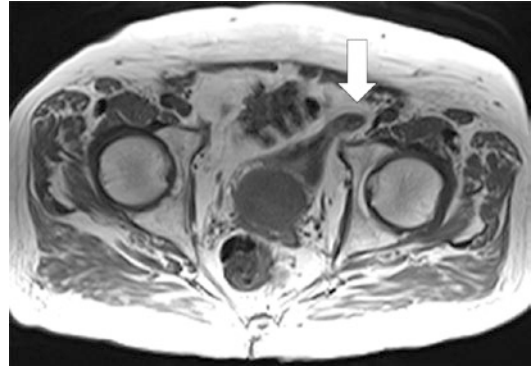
Axial T2-weighted image through the pelvis demonstrates herniation of the urinary bladder into the left inguinal canal (arrow)
